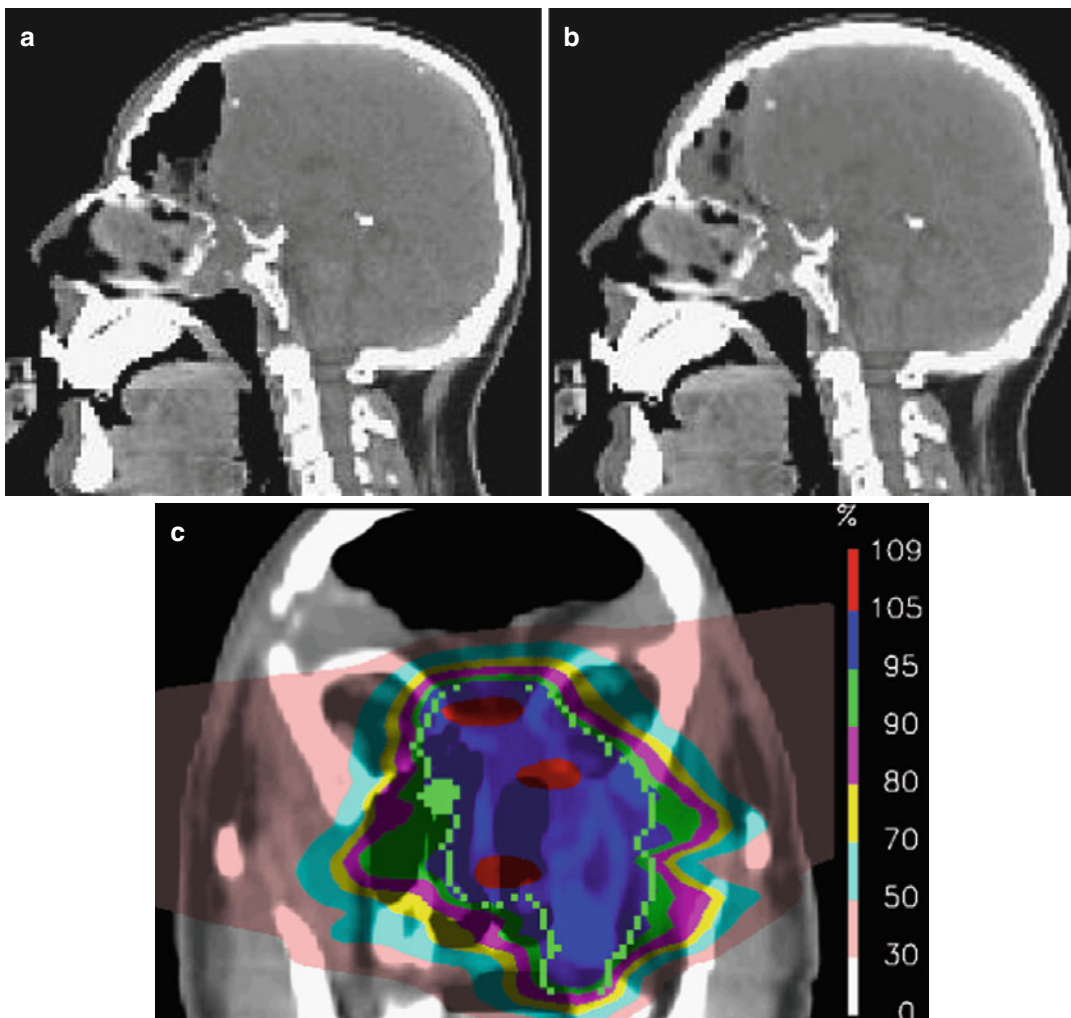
Postoperative anatomical changes in the brain: (a) Planning CT, (b) Repeat CT 2 weeks into treatment, (c) Actual plan delivered to avoid the air cavity (frontal view)
